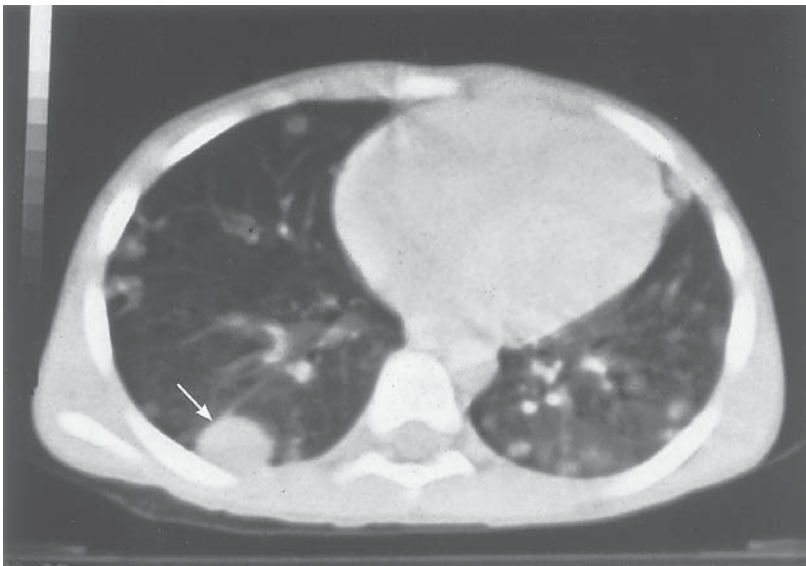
In a patient undergoing evaluation for nephrectomy, a preoperative chest X-ray demonstrated a right lower-lobe lung lesion. Chest CT scan demonstrates the dominate right lower-lobe pulmonary nodule [arrow] with multiple bilateral metastases.
